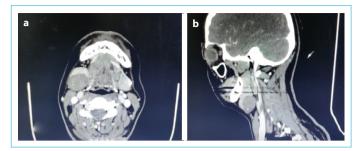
(a) The axial view of well-defined border of the left submandibular mass in the computed tomography scan. (b) The coronal view of the mass located at left submandibular in the computed tomography scan.
